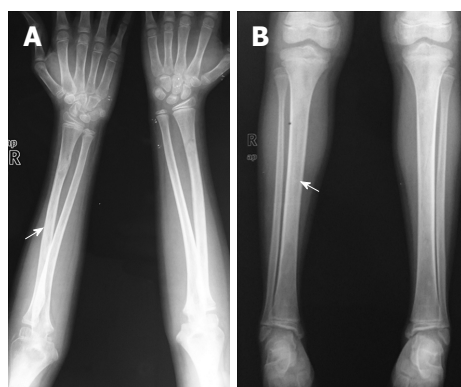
Anteroposterior radiographs of both forearms (A) and both legs (B) showing symmetric bilateral osteosclerosis of the metaphysis and diaphysis of the long bones (arrows).
